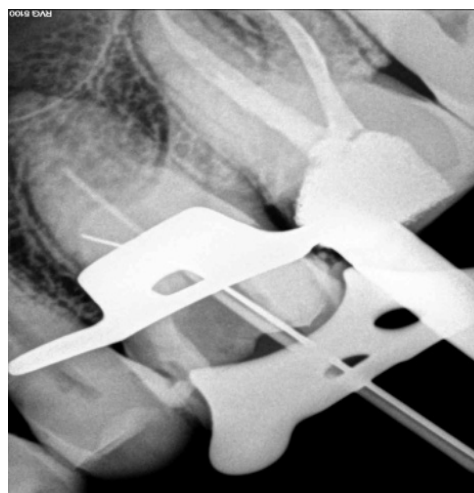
a. Preoperative radiograph
